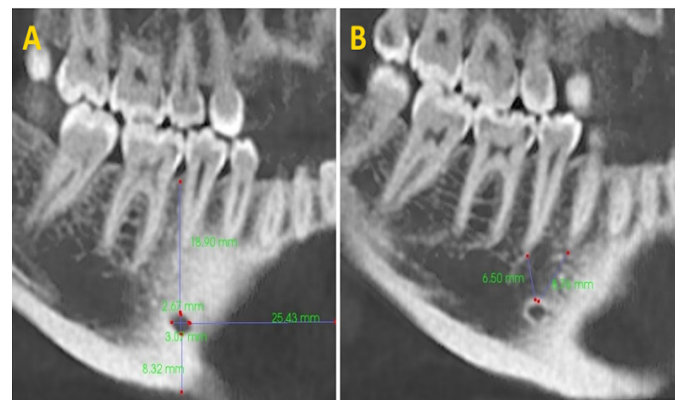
Measurements of the mental foramen on cone-beam computed tomography : the distance of the mental foramen to the midline and the upper-lower border of the mandible (A), the distance of the mental foramen from the roots of the 1st and 2nd premolars (B)
